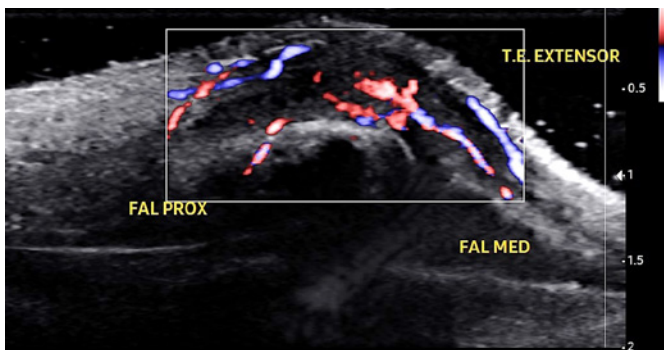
Directional power Doppler showing hypervascularization of the tendon.
